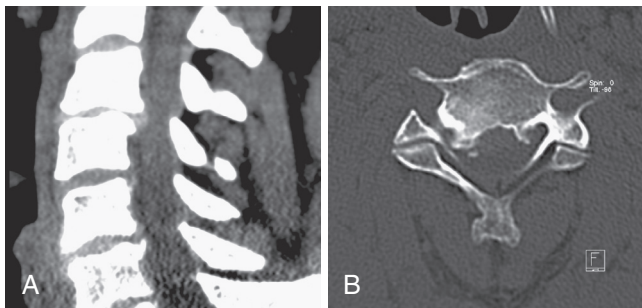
CT images of C3-4 hard cervical disc herniation.
